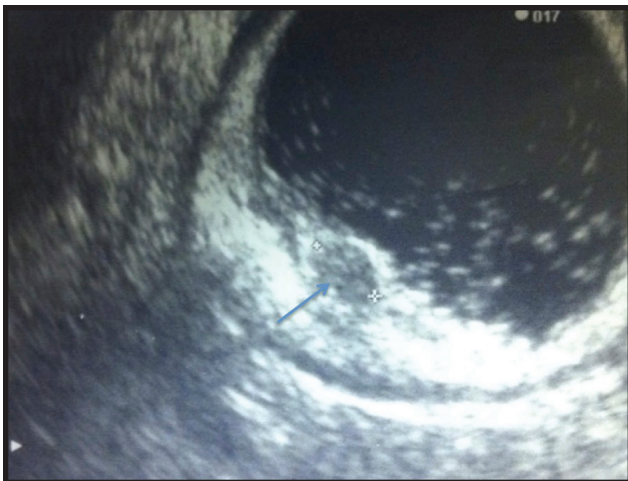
Endoscopic Ultrasound view. Arrow shows a hypoechoic lesion arising off the submucosa layer
